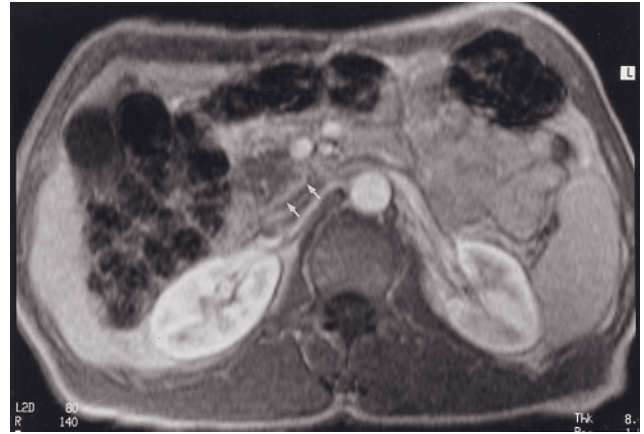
Nonfunctioning well-differentiated neuroendocrine carcinoma. T2-weighted SS-ETSE (*a*), T1-weighted SGE (*b*), T1-weighted fat-suppressed SGE (*c*), immediate postgadolinium T1-weighted SGE (*d*), and 90-s postgadolinium fat-suppressed SGE (*e*) images. There is a exophytic mass (arrows, *b*) arising from the head of the pancreas, which is slightly hyperintense relative to the pancreas on T2 (*a*) and moderately hypointense on T1 (*b*, *c*) with mild early (*d*) and late (*e*) enhancement on gadolinium-enhanced images.
